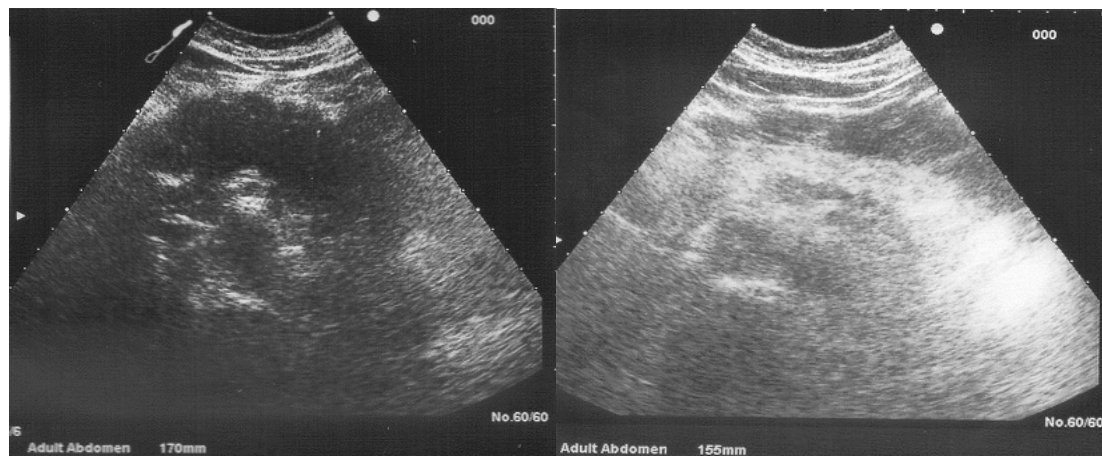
Ultrasound of the pancreas before (left) and after the therapy with corticosteroids (right).
